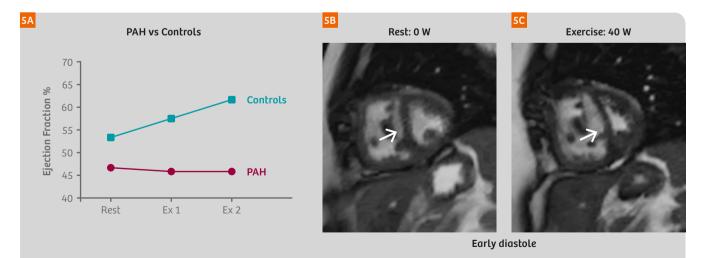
Exercise MRI unmasks RV dysfunction not evident at rest in patients with pulmonary arterial hypertension (PAH): Despite having near-normal RV function at rest, PAH patients were unable to increase their RV contractile function during exercise.
